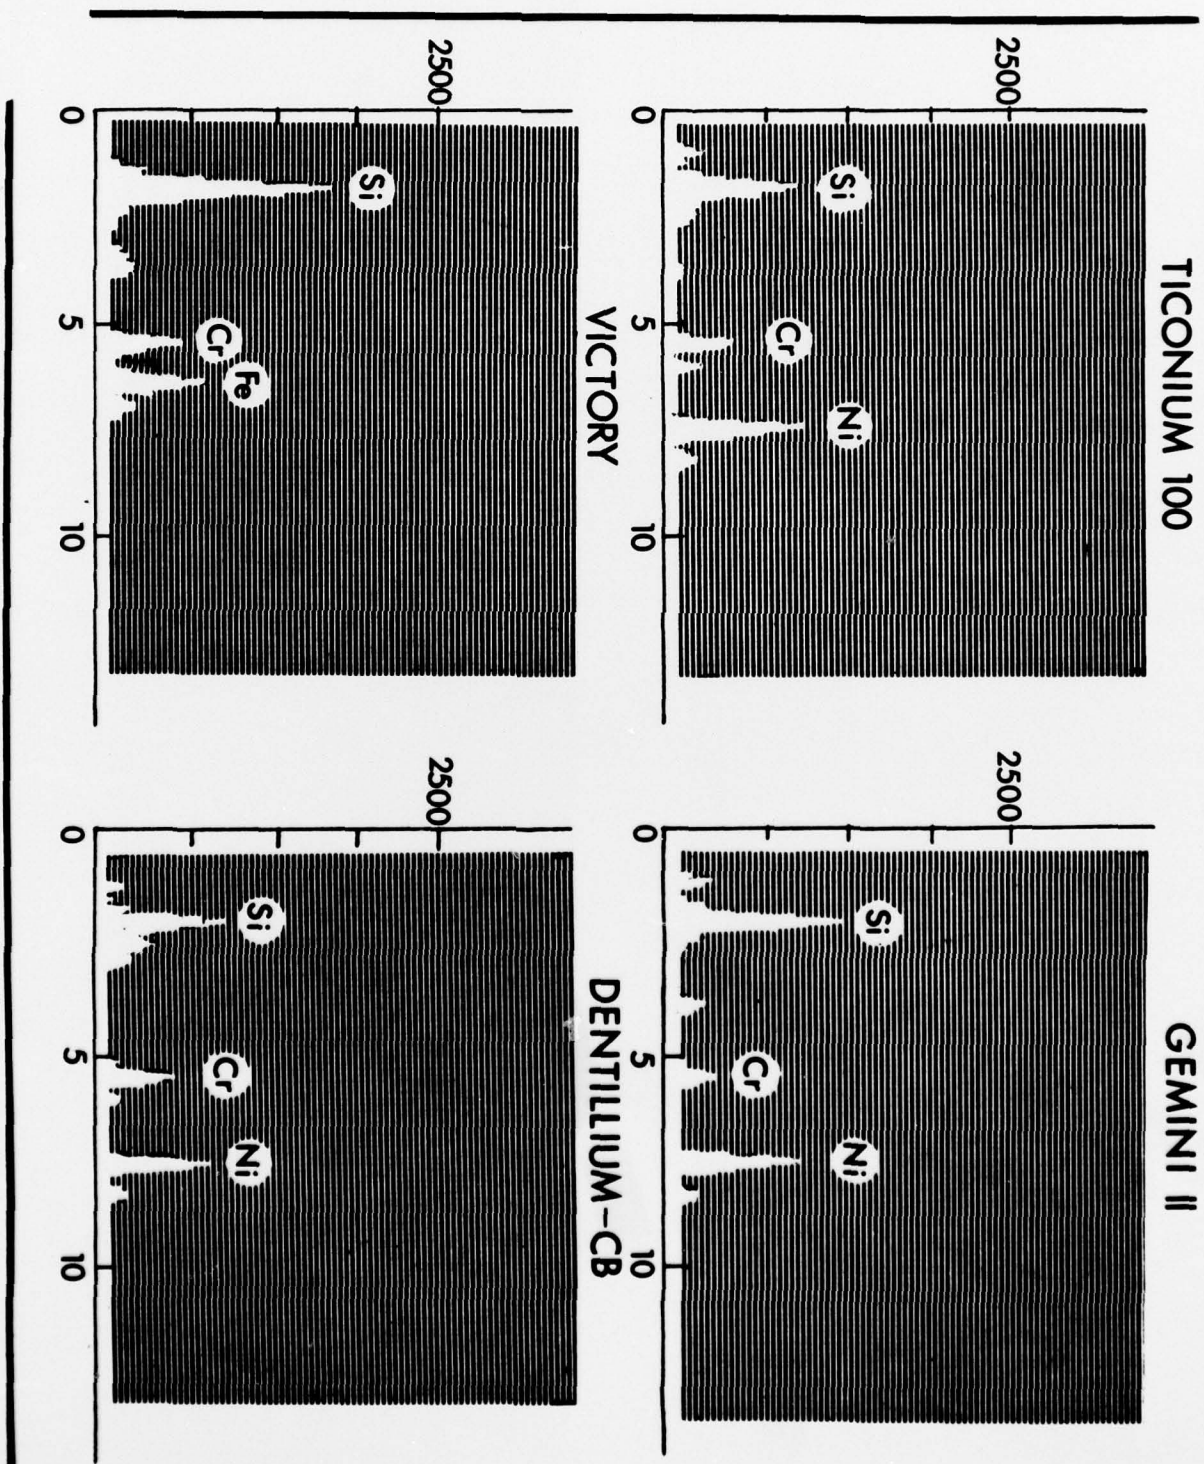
X-RAY ENERGY, ke V
